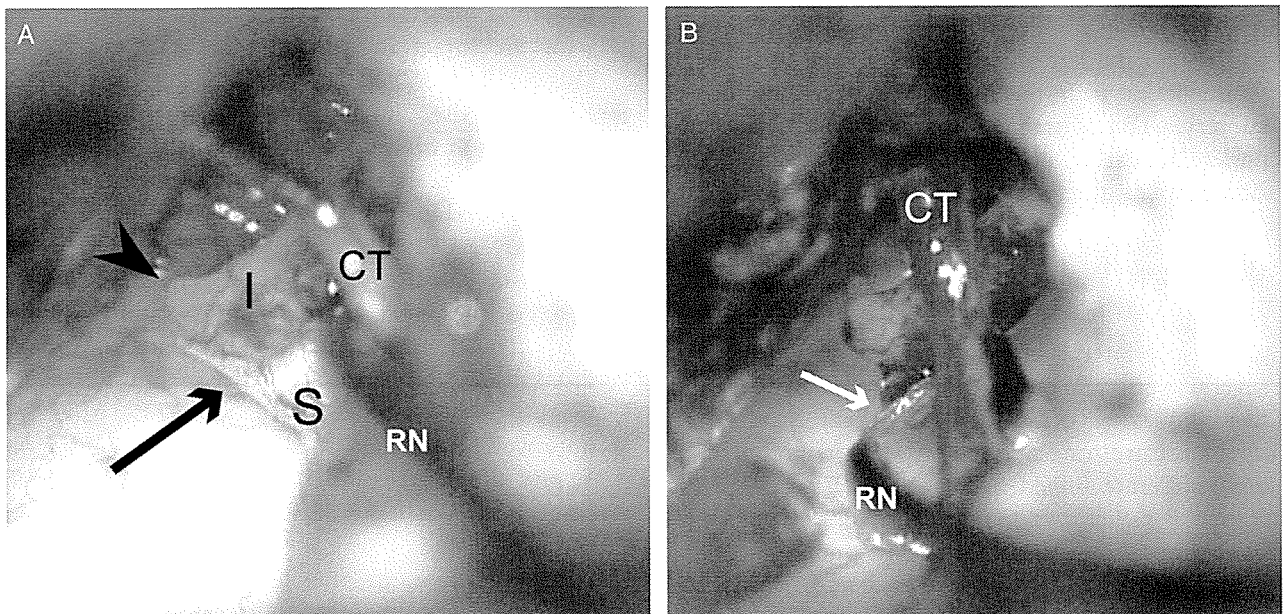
Findings during surgery of the left side. (A) A small pinched part near the incudostapedial joint was found (arrow). This part lacked bone and connected only with normal mucosa that covered the bone. A small protuberance on the incus just above the discontinued part was noted as combined malformation (arrowhead). (B) A particle of external canal bone (arrow) was inserted into the discontinued part with a Rosen needle. I, long crus of incus; S, stapes head; CT, chorda tympani; RN, Rosen needle.
